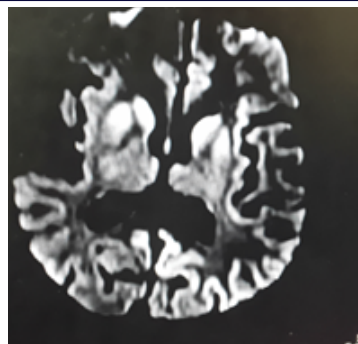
DWI (Diffusion weighted Images) shows restriction in the bilateral basal ganglia. cortical areas of restricted diffusivity(cortical ribbon sign)
